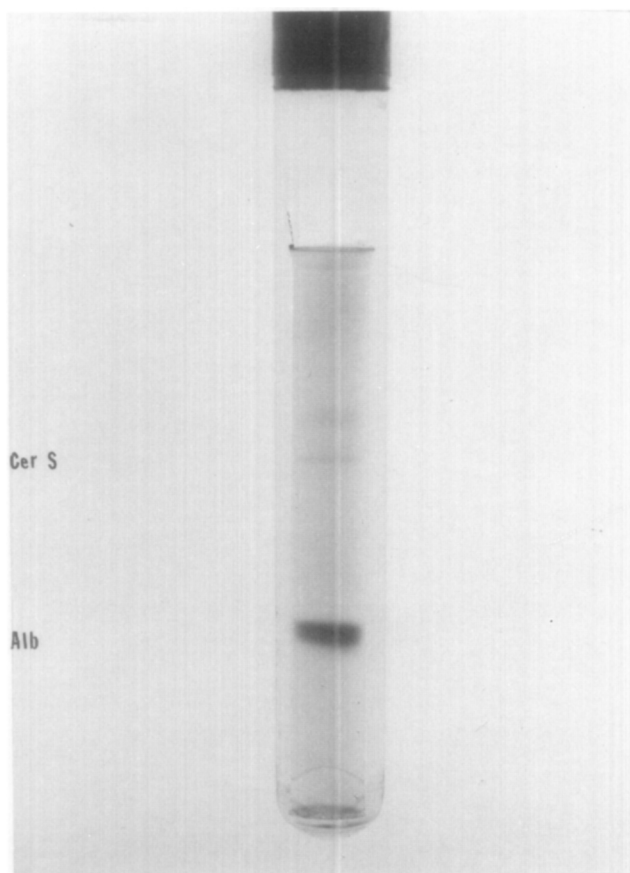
Polyacrylamide-gel electrophoretic patterns from Case 37; pulpless upper left central incisor with no periapical pathosis and necrotic contents in canal. *Alb*, Albumin; *Cer S*, slight pattern in ceruloplasmin region.
